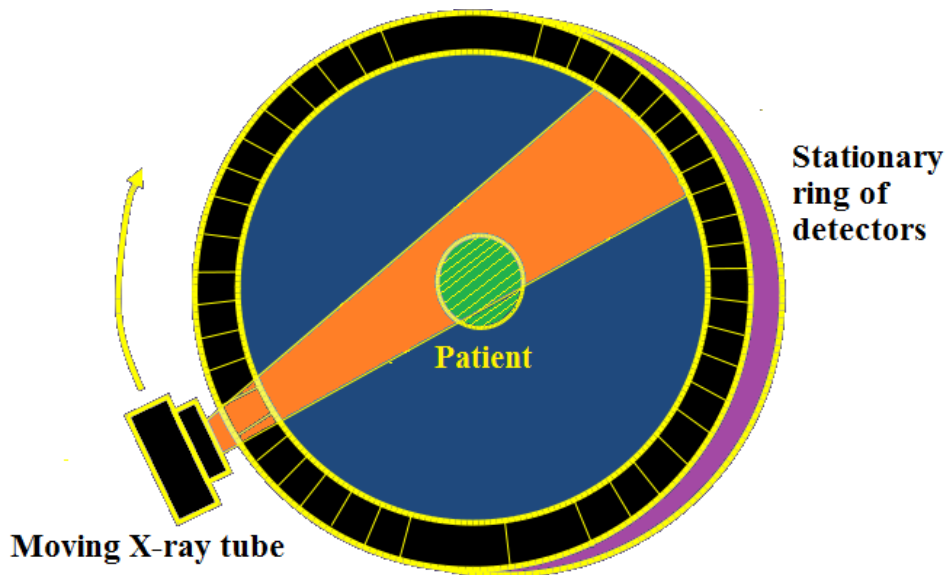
CT acquisition. The moving X-ray tube projects X-ray beams towards the patient (or more specifically the temporal bone in our case). The residual beams reach the detector creating a pseudo X-ray image. The acquisitions from multiple tube locations can provide a 3D image.
